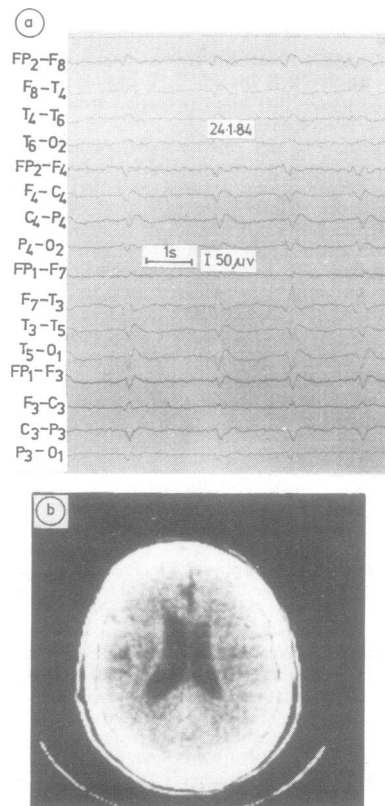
Fig (A) EEG shows left temporal dominant periodic slow wave discharges. (B) CT scan demonstrates ventricular enlargement and left parietal low-density lesion.
